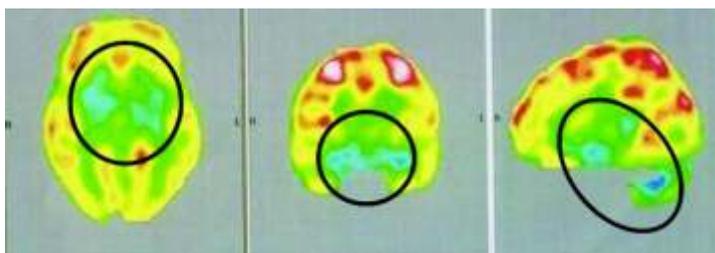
PET-CT scan 8 months after second cellular transplantation showing maintained increase in the metabolism of superior temporal gyrus, mesial temporal lobes, amygdala, hippocampus, cingulate regions and cerebellum and reduction in the metabolism cortical regions showing the balancing effect
